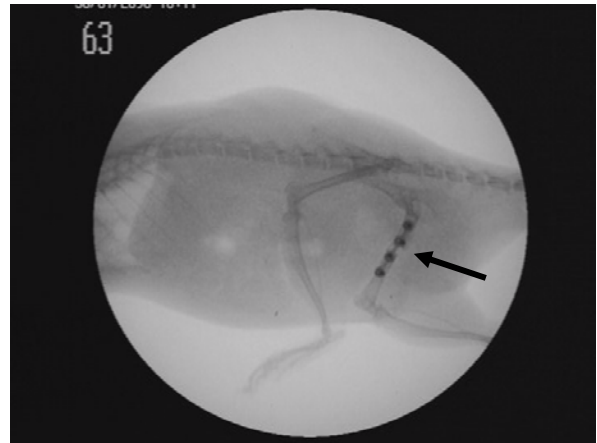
A radiograph 5 days after the implantation showing (arrow) the location of the implant
